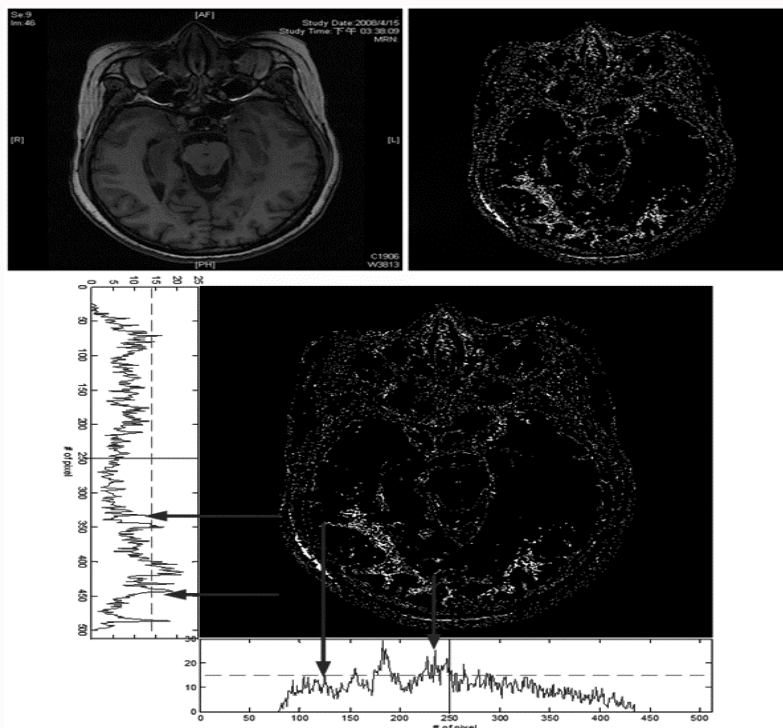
Left, top: the original MR image of the patient No. 1. Right, top: corresponding result of fuzzy index matrix I of the MR image. Bottom: Fuzzy elements were horizontally and vertically summed to locate the suspected areas of cerebral cortical malformation.
